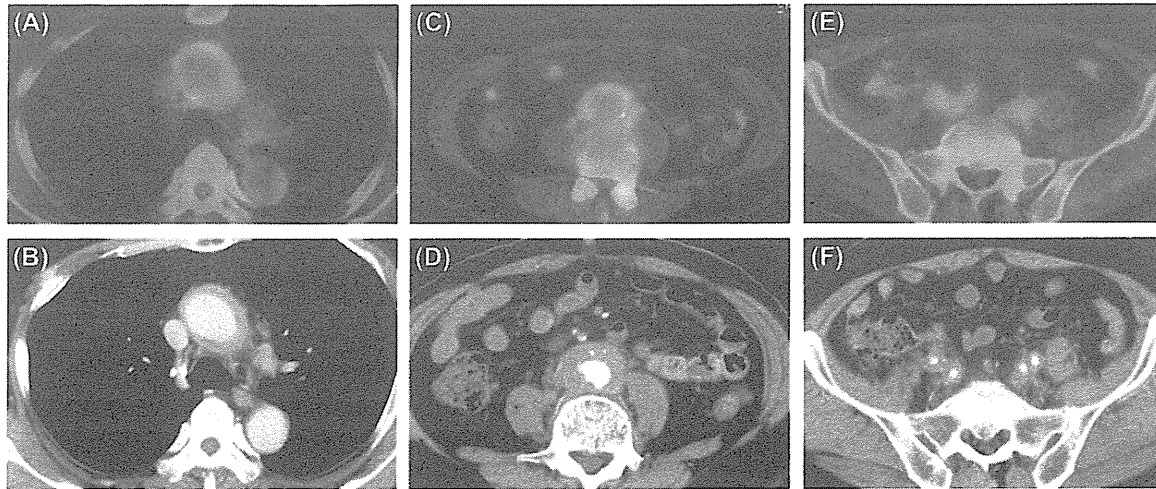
Positron emission tomography-computed tomography and contrast-enhanced computed tomography of perivascular lesions in Case 2. (A and B) Thoracic aorta, (C and D) abdominal aorta, (E and F) Iliac artery. A, C, and E are images obtained by positron emission tomography-computed tomography (PET-CT). B, D, and F are images obtained by contrast-enhanced computed tomography (enhanced CT).
